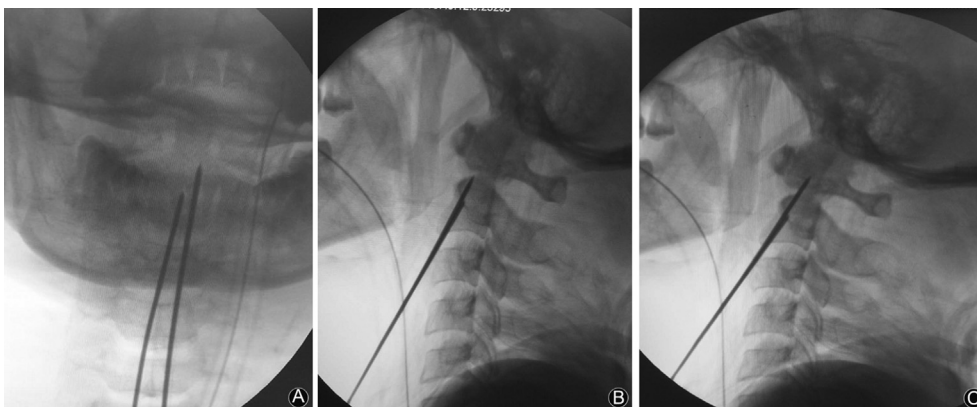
The intraoperative anteroposterior (A) and lateral (B) radiographs showed that we used two guide wires to fix the C<sub>2</sub> vertebral. The intraoperative lateral (C) radiograph showed the odontoid process was still displaced to the front of the wire.
